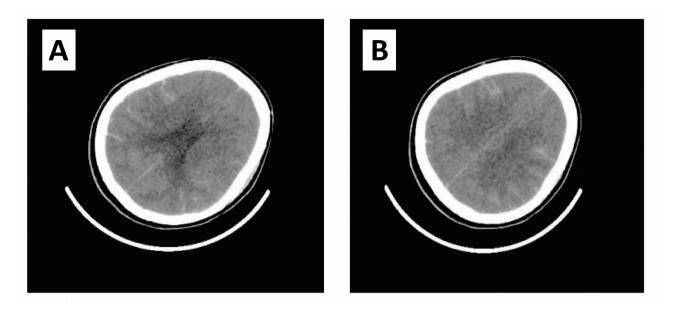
Imaging results of the patient on October 15. (A, B) CT of the brain. There are multiple high-density shadows in the cisterna of the new sulcus, which indicate subarachnoid hemorrhage. Additionally, there are unclear hypodense shadows in the original right basal ganglia-right lateral paraventricular and left frontal lobe patchy, and no expansion of the supratentorial ventricles
